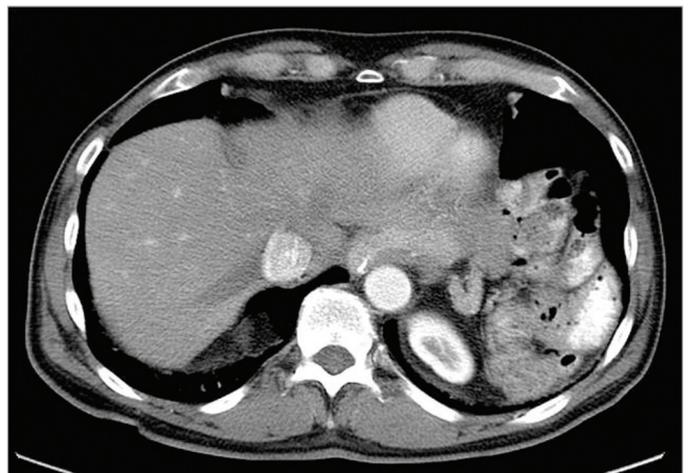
CT scan from October 2008 after IL-2 treatment showing a hepatic metastasis that had grown slightly after IL-2 therapy. Measurements of lines 1 and 2 are 12.8 and 22.1 mm, respectively.
